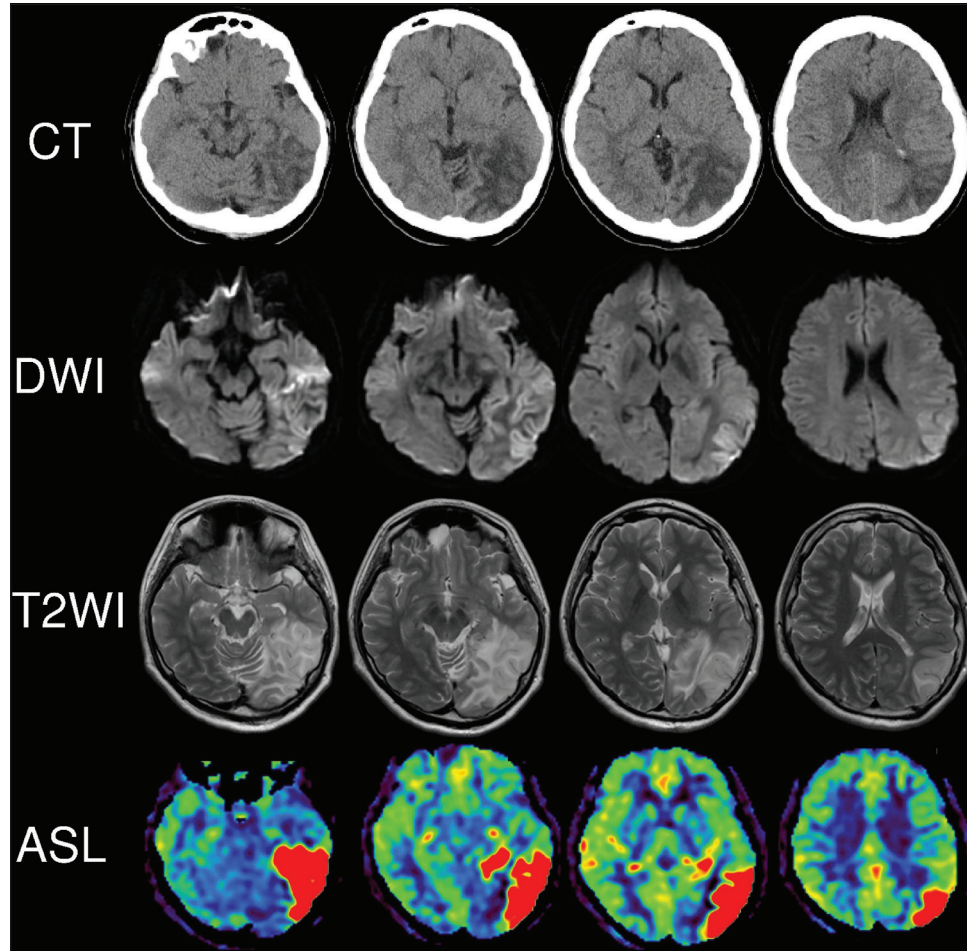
Neuroimaging on day 12. Head computed tomography revealed an enlarged low-density area in the left parieto-occipital lobe. The diffusion-weighted image and T2-weighted image also showed the enlarged high-intensity area, and arterial spin labeling image described further cerebral blood flow increase in the same region.
